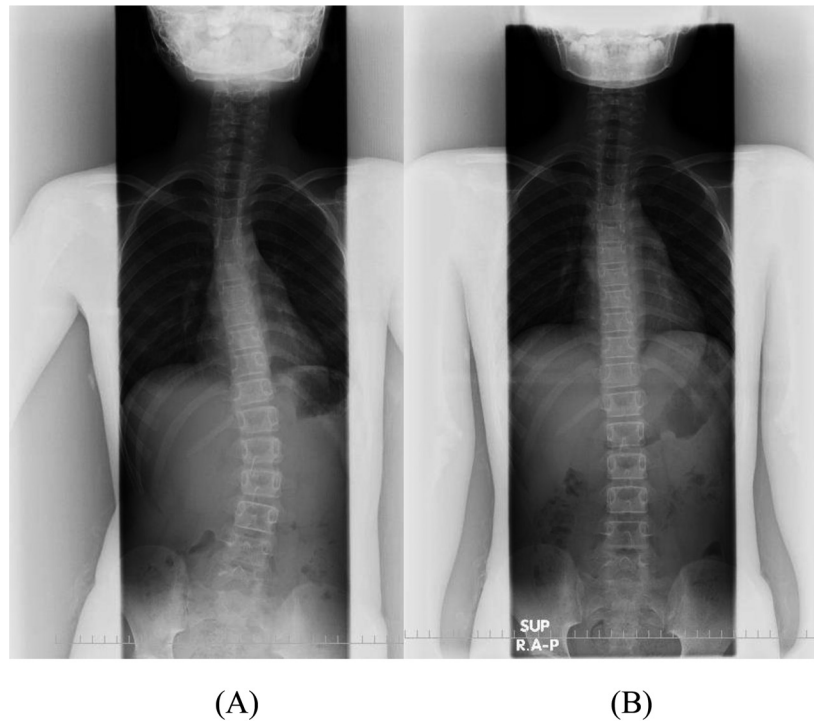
Radiography of the spine of the patient. (A) Scoliosis is evident in the standing position. (B) In the supine position, the scoliosis is improved.
